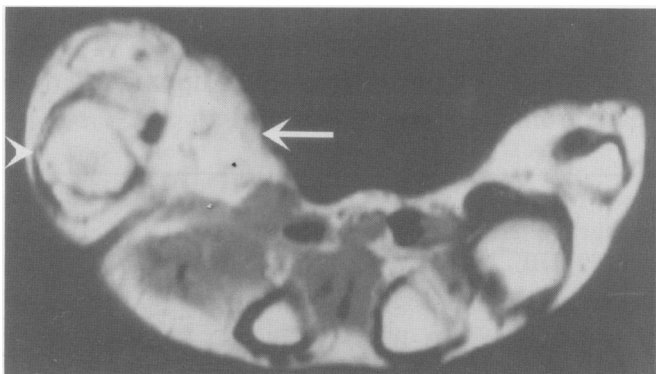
Axial T1 weighted MRI of right thumb again showing the surrounding excess high signal fatty tissue (white arrow). The first metacarpal is labelled (white arrowhead).
